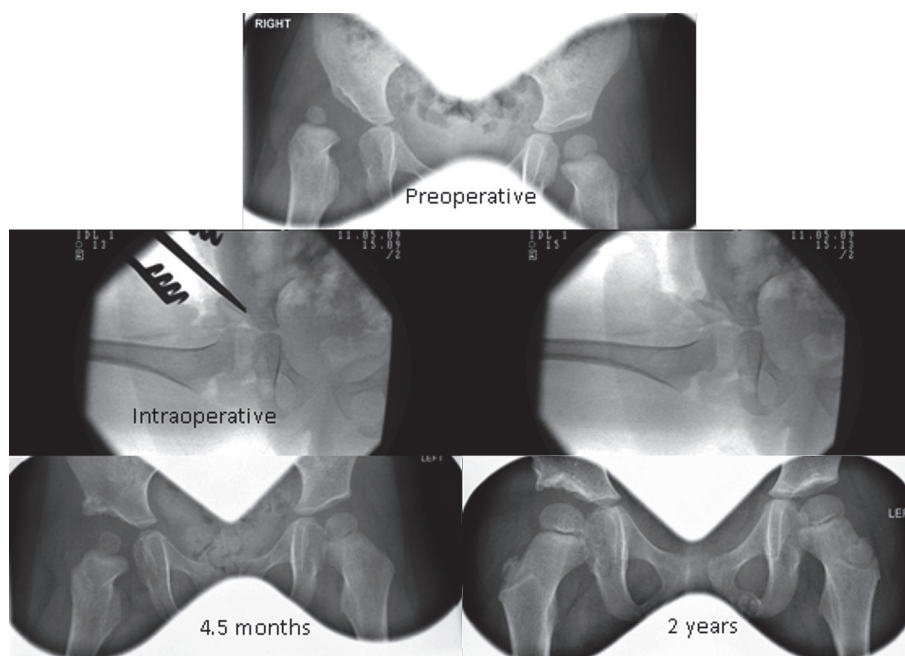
Comparison of preoperative and postoperative radiographs at 4.5 months and 2 years.
